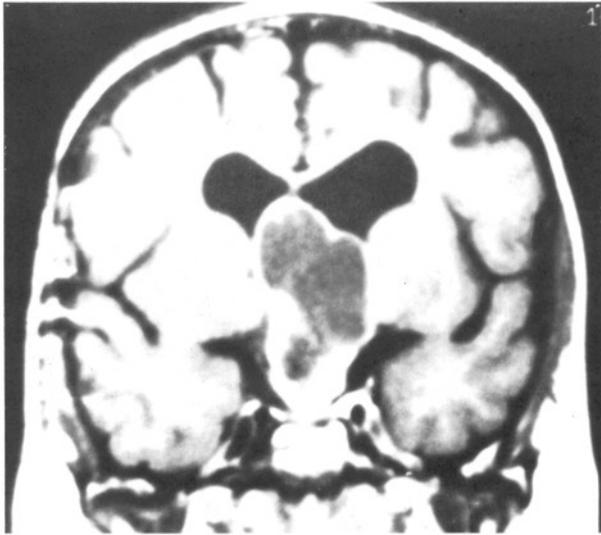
Sagittal view of MRI scan showing suprasellar cystic tumor.
